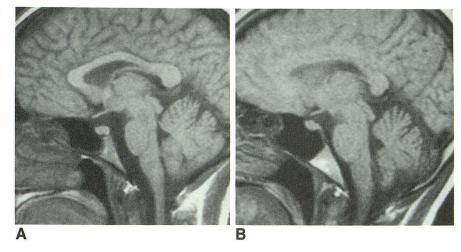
Grade 2 normal clivus with mixed signal intensity in a 77-year-old man. T1-weighted midline sagittal scan, SE 600/20 (1.5 T), shows a normal clivus with mixed low and high signal intensity. Area of low signal intensity is less than 50% but greater than 20% of entire marrow space. Low-signal-intensity area is hyperintense relative to pons. There are a few foci of bright signal intensity in low-signal-intensity portion.
